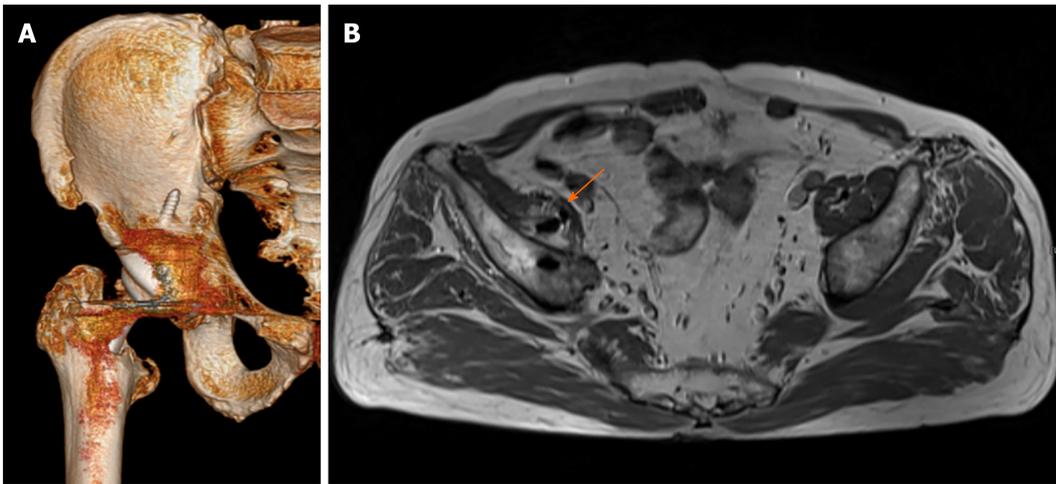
Advance images showing screw protrusion. A: Three-dimensional reconstruction of a computed tomography image showing the screw penetrating through the ilium; B: Magnetic resonance imaging showing the screw penetrating through the iliopsoas muscle (arrow).
